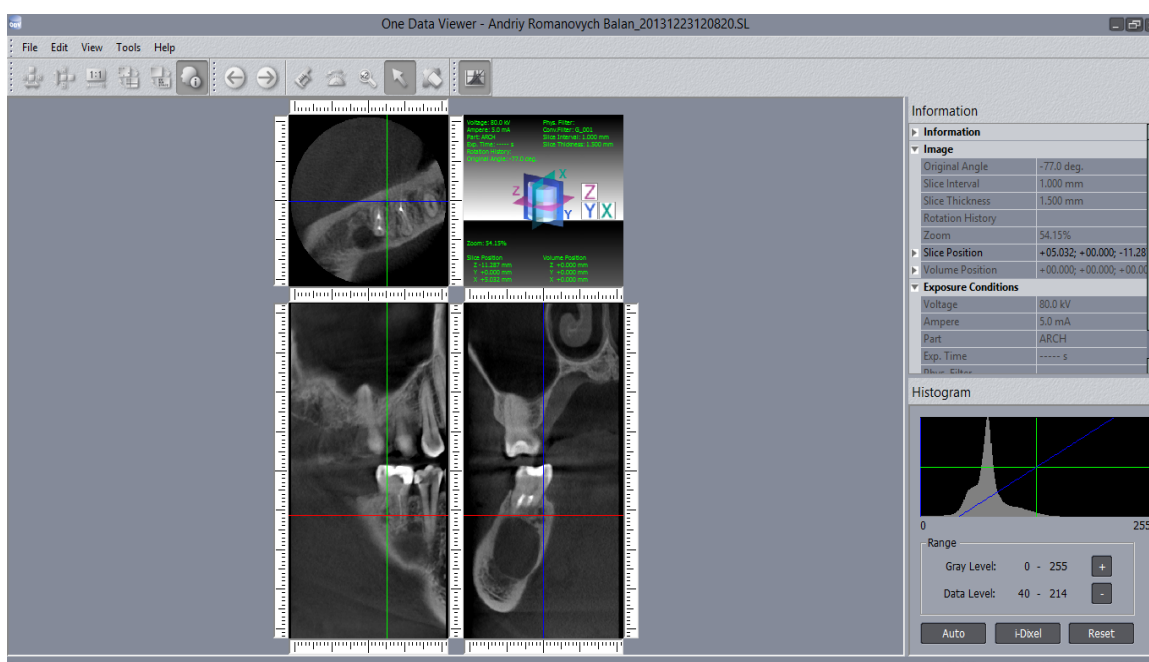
Study of the state of bone tissue in patients using cone-beam computed tomograph Morita
